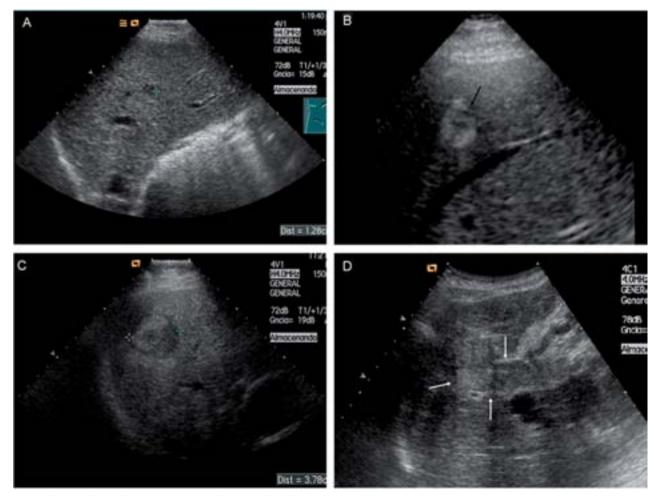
Different patterns of the HCC ultrasound. A) A small hypoechoic nodule that is 13 mm in size in the right hepatic lobe (cursors). B) Echogenic nodule 1.7 cm in size (arrow). C) A heterogeneous nodule that is 3.7 cm in size, with a hypoechoic halo, in the dome of the right lobe (cursors). D) Extensive portal thrombosis that translates to vascular tumoral invasion in a patient with multinodular HCC (arrows).
